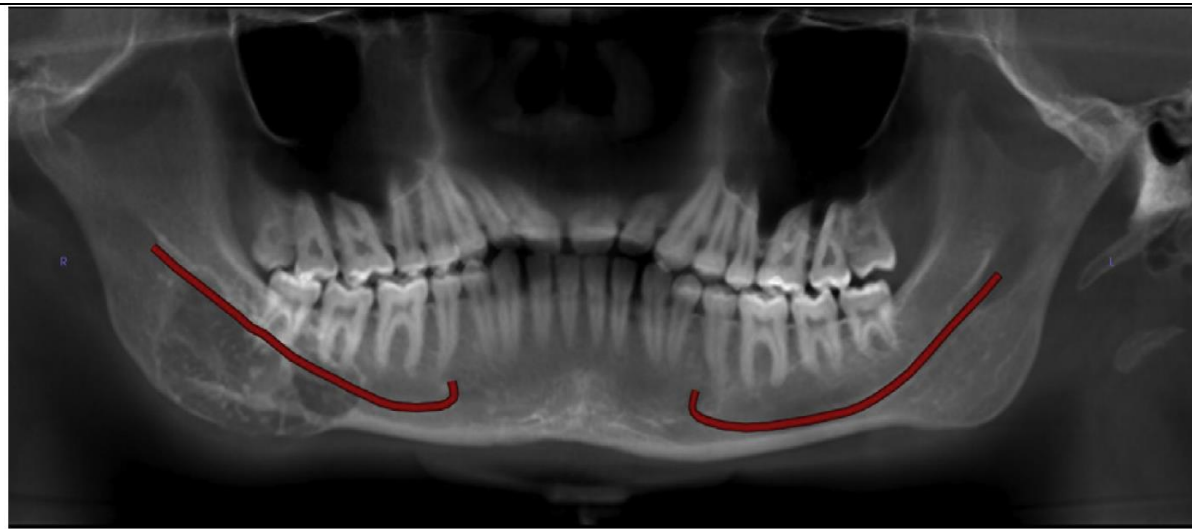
Reformatted panoramic cone-beam computed tomographic image shows a well-defined radiolucent lesion with internal calcifications in the right posterior mandibular body and angle region. The epicenter of the lesion is inferior to the mandibular canal (red). Note the superior displacement of the canal
